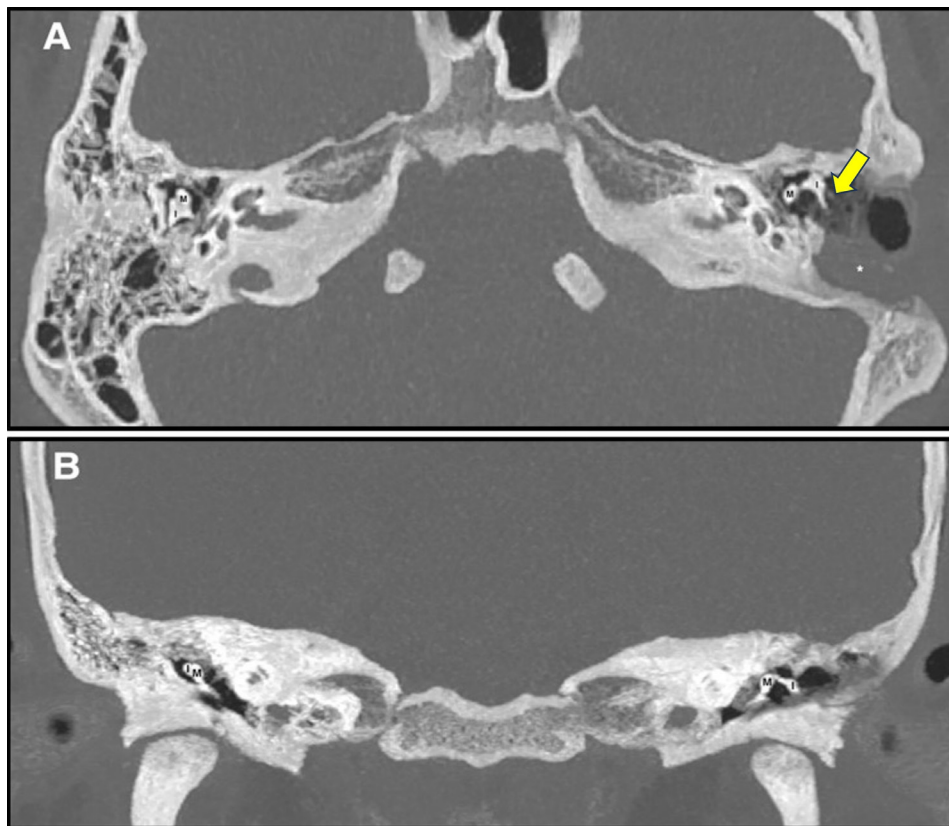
A HRCT image in (A) axial view shows disrupted left incudomalleolar joint as compared to a normal configuration seen on the right ear. The incus (I) is dislocated laterally in relation to the malleus (M). A soft tissue density is seen around the short process of the incus causing mild erosion at its lateral aspect and the long process of the left incus was eroded and shortened (yellow arrowhead). (B) A HRCT coronal view showing the laterally displaced left incus. There are soft tissue densities adjacent to it and in the left mesotympanum lying medial to the left malleus.
